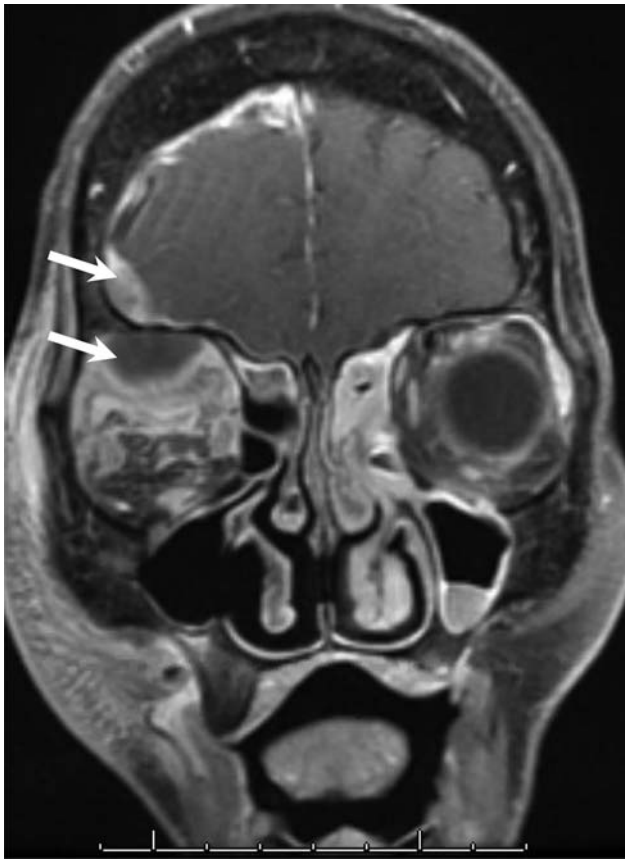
Preoperative coronal, post contrast MRI showing orbital and epidural abscess (arrows), presumed to be extending from the frontal sinus.
